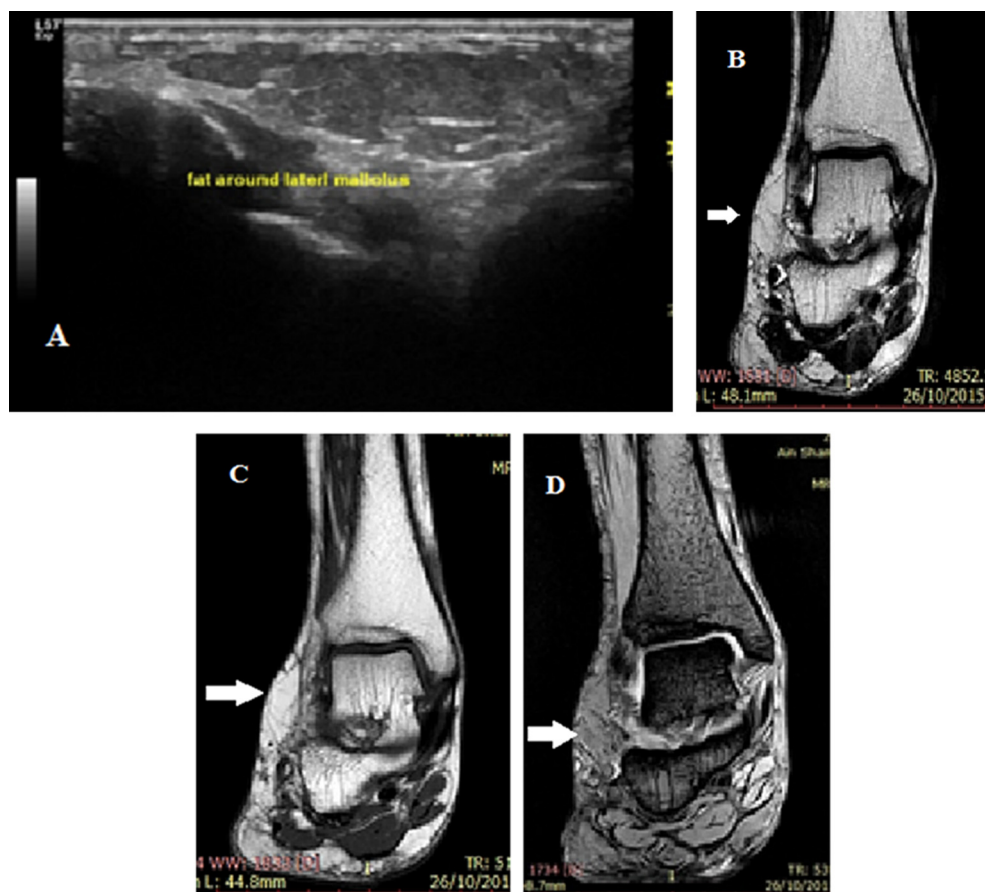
A. Longitudinal US image around lateral malleolar swelling formed of fat lobules (fat echogenicity). MRI coronal images B. T2WI and C.T1WI and D. STIR images show a swelling that displays a fatty signal on both T1 and T2WIs with complete signal suppression at STIR images denoting a subcutaneous lipoma (white arrow).
